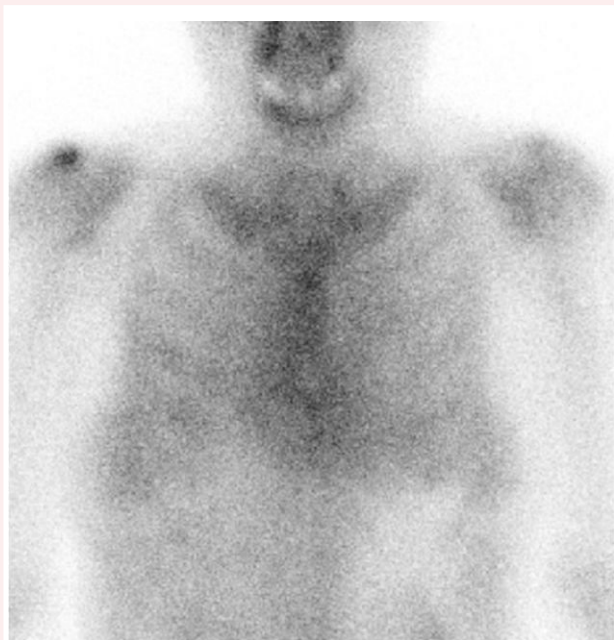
^{99m}Tc -pyrophosphate scintigraphy showed Grade 1 uptake was detected in the right ventricle and right atrium.
